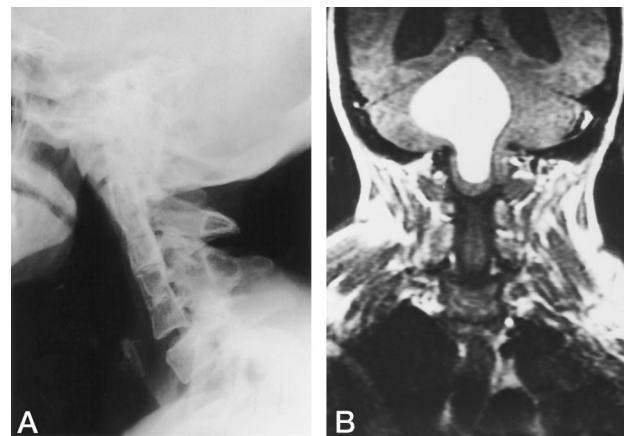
A, Lateral cervical spine radiograph shows the fusion of cervical vertebrae, pituitary fossa erosion secondary to chronically raised intracranial pressure, and calcification projected over the posterior fossa.
